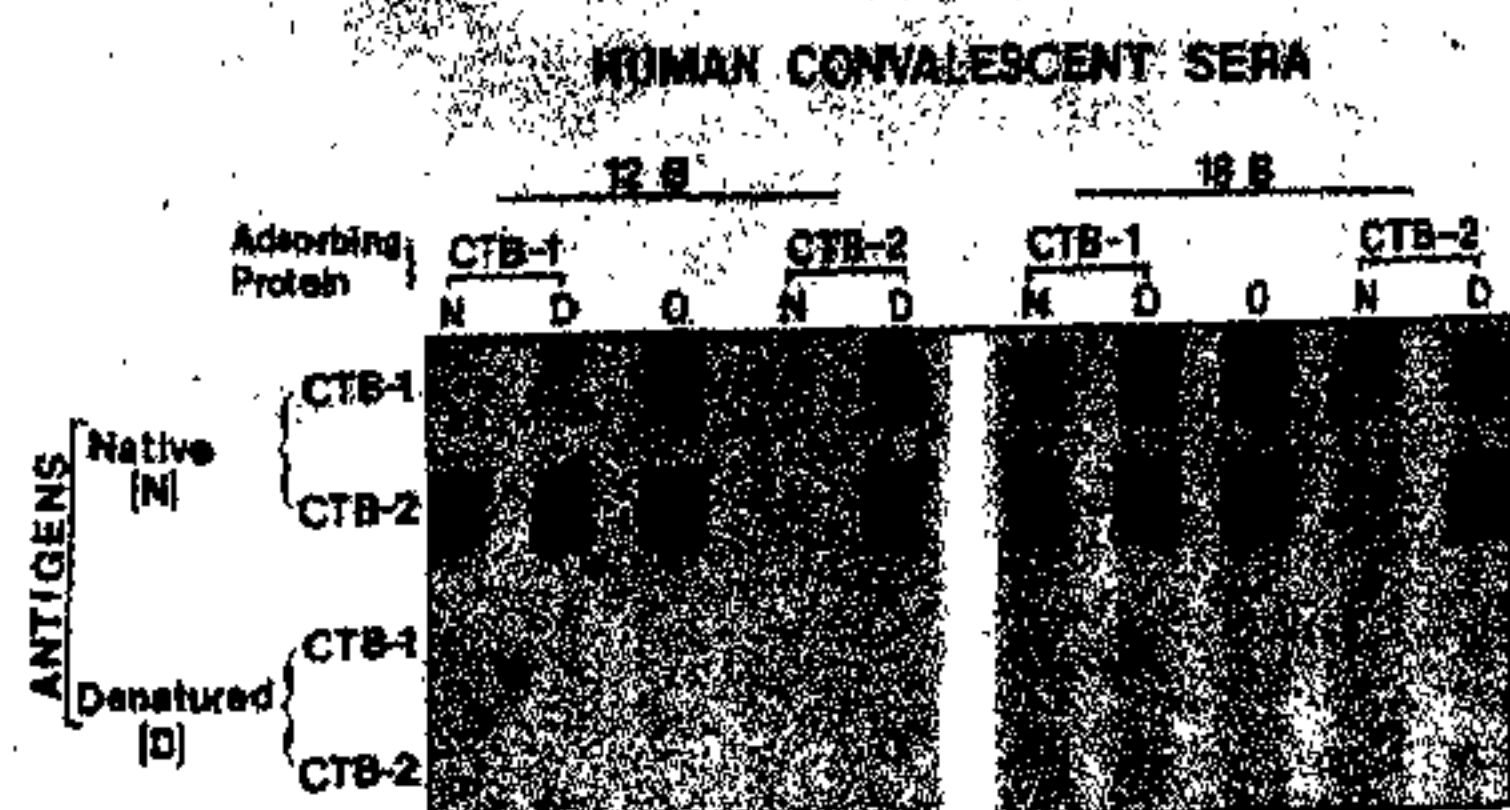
Checkerboard immunoblot (CBIB) analysis of sera from two volunteer cholera convalescents, 12B and 18B, unadsorbed (O), adsorbed with native protein (N) and adsorbed with denatured protein (D), tested with native (N) and denatured (D) CT-B-1 and CT-B-2.
